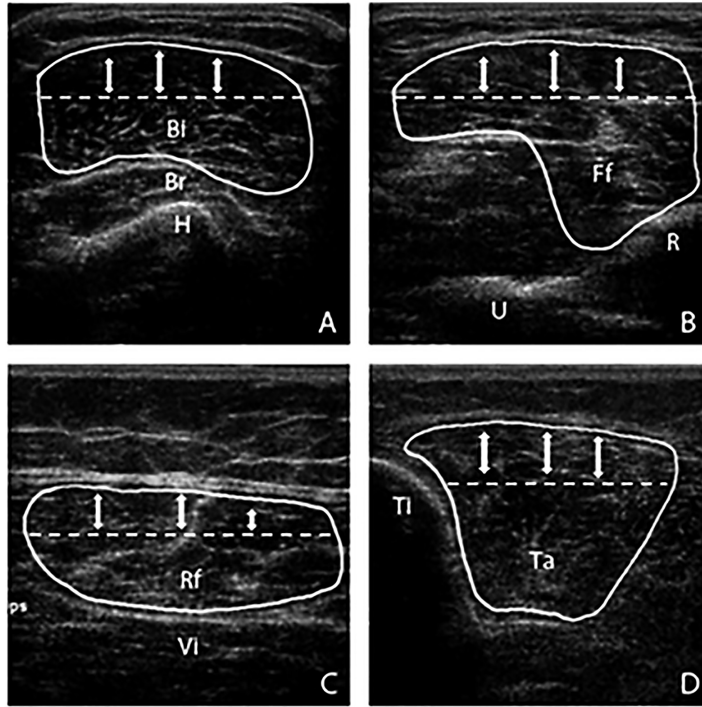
Quantitative ultrasound measurements were performed for the biceps brachii muscle (A), forearm flexors (B), rectus femoris muscle (C) and tibialis anterior muscle (D).
